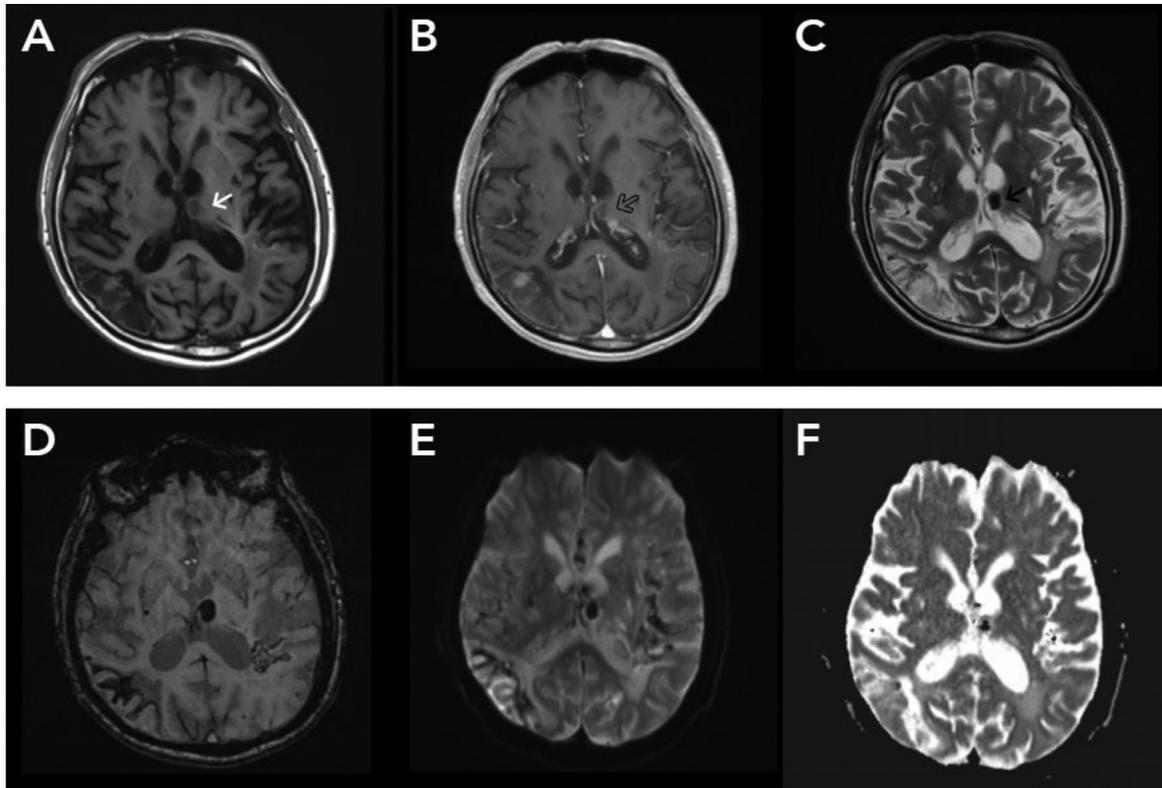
Nodular calcified stage at left thalamus seen on axial view T1-weighted image (A), Postcontrast T1-weighted image (B), T2-weighted image (C), SWI (D), DWI (E), and ADC (F) showing spherical lesion with well-defined border, diameter of 1.20 cm with hypointense on T1-weighted image (A, white arrow), no signal on T2-weighted image (C, black arrow), and blooming artefact on SWI (D). No restricted area was seen within the lesion on DWI and ADC (E, F).
